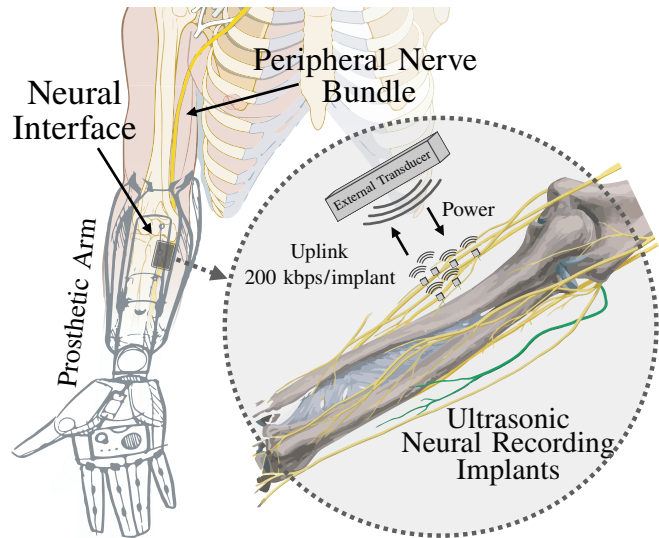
Concept of active prosthetic arm control using a distributed network of ultrasonically powered peripheral nerve implants.
